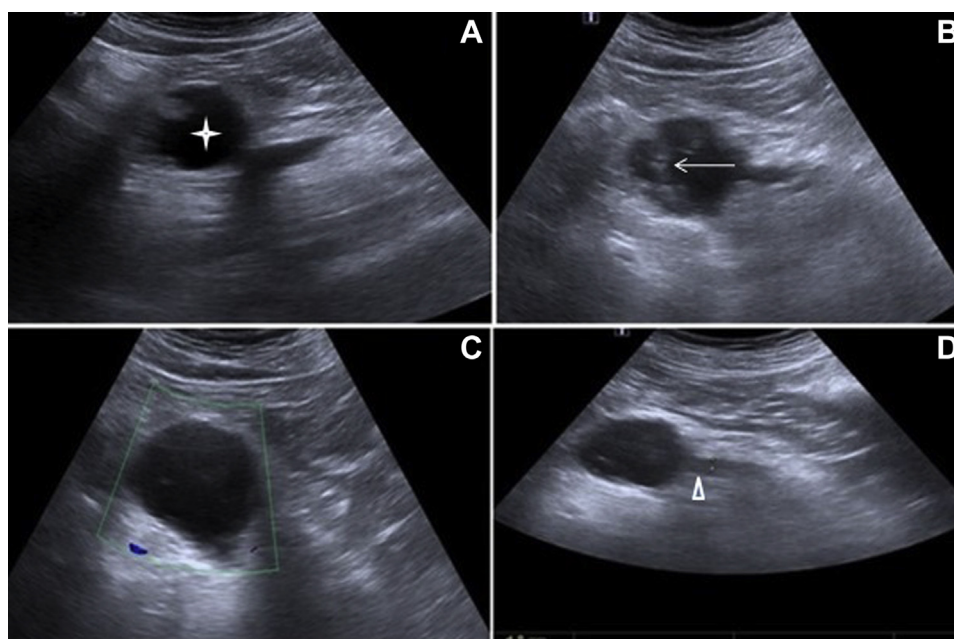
The segmental cystic dilation of the main pancreatic duct in the abdominal US (A, B) on the body of the pancreas, bordering the lobule, associated with the dilated pancreatic duct (asterisks); solid components projecting into the lumen in the periphery (long arrow). No flow was observed within the lesion in colored Doppler US (C). The main pancreatic duct is 4.8 mm in width (arrow head) in the US (D). The sub-branch dilation seen in the MR cannot be distinguished.
